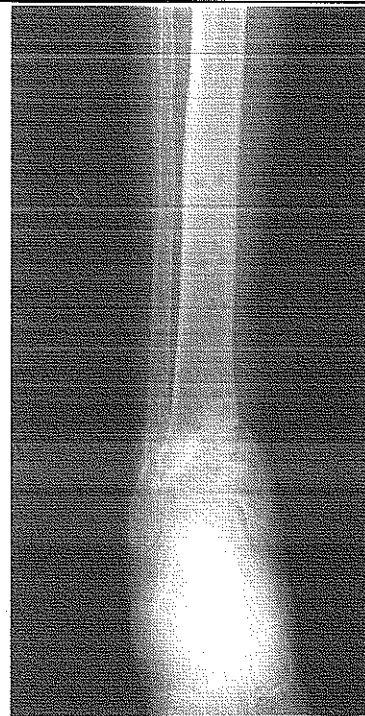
X-ray 6 months later, after bone implant had been removed.
